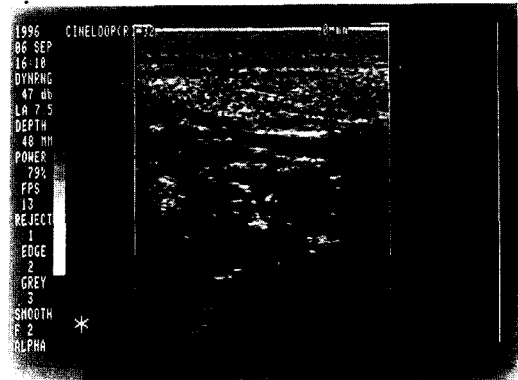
Ultrasonography of submandibular gland on heat-sensitive paper
